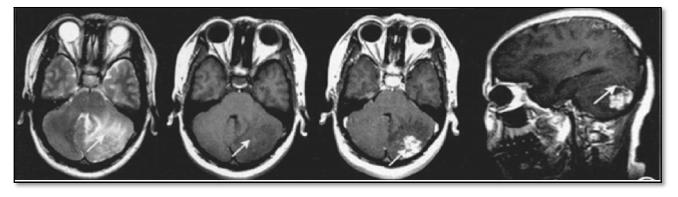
The MRI features of syphilitic granuloma: tubercular and uneven enhancement in the left cerebellum, surrounded by large heterogeneous enhancement edema.(from literature [3])
